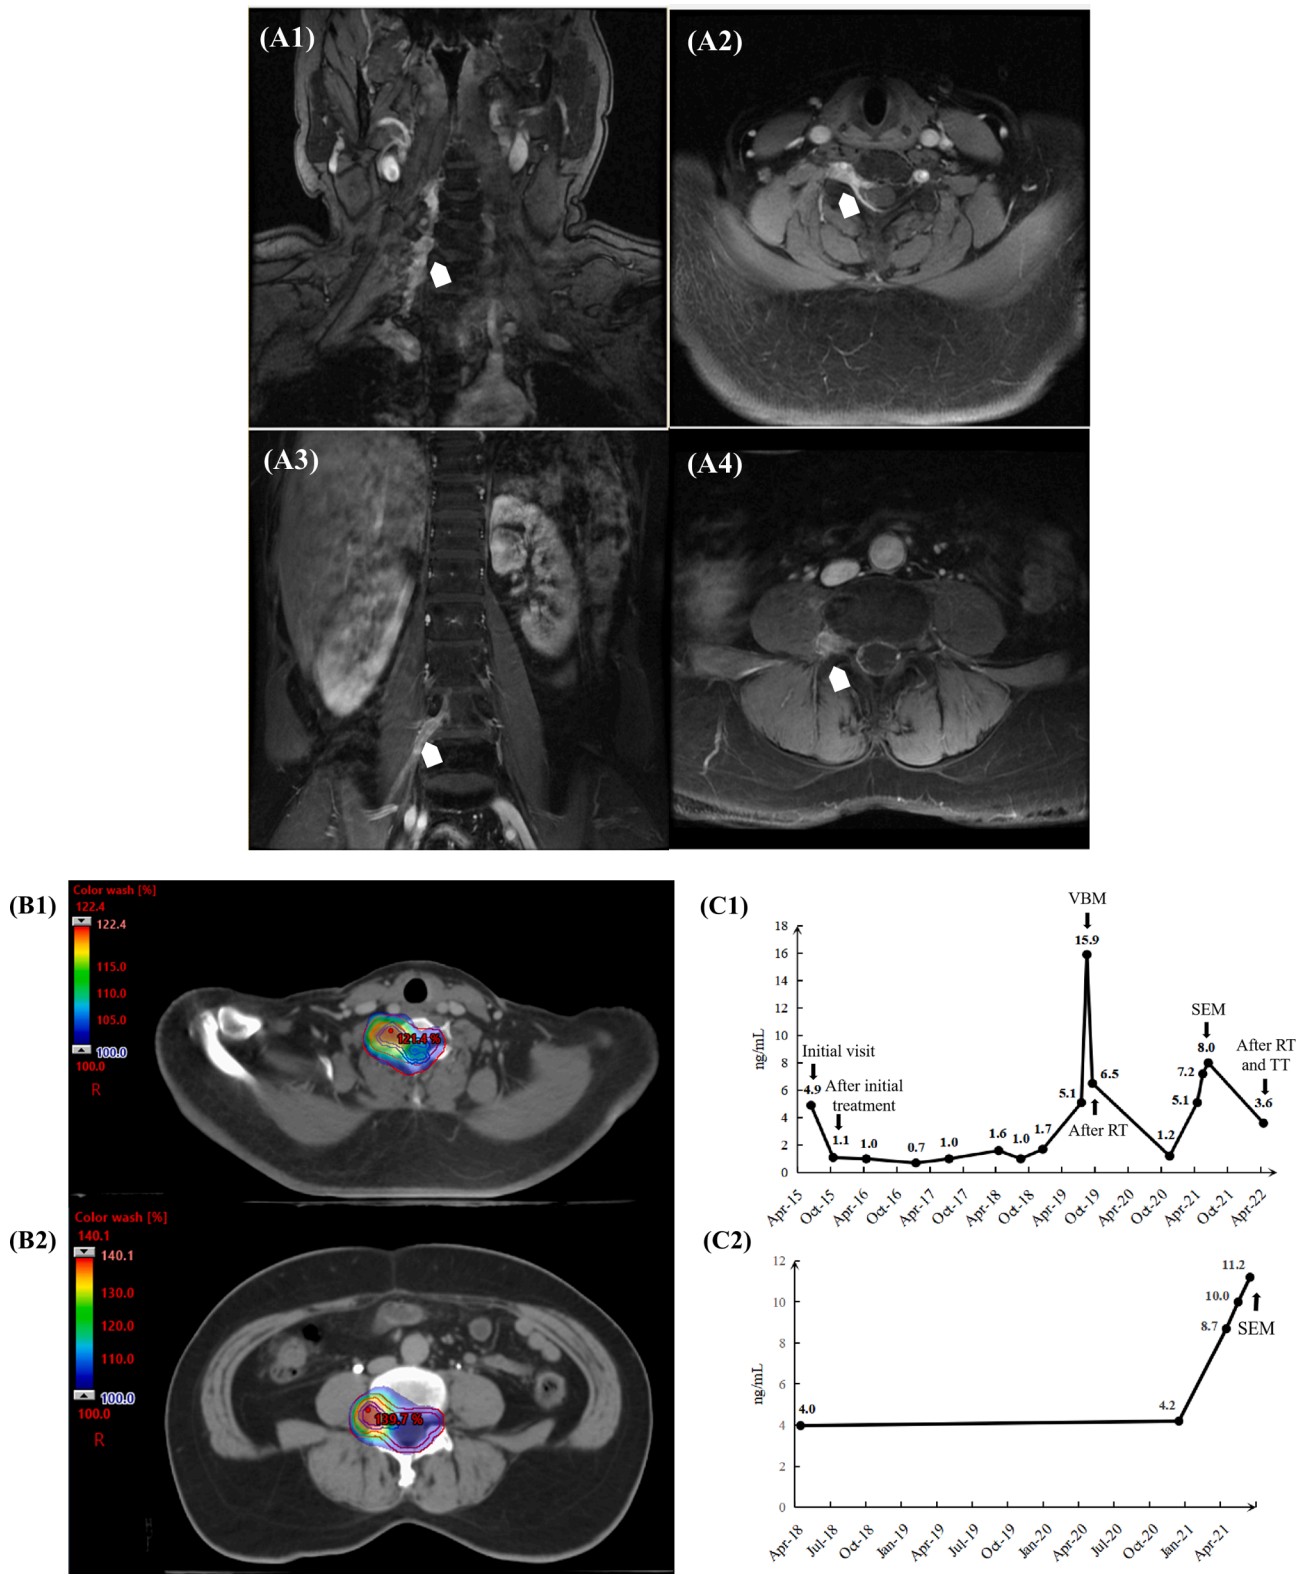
Case 2. (A)MRI: Cervical magnetic resonance imaging showed abnormal enhancement of spinal dura mater and widen right intervertebral foramen at C5-7 level. Coronal image(A1) and horizontal image(A2). Lumbar magnetic resonance imaging showed nodular obvious enhancement within dural sac at L3-4 level. Coronal image(A3) and horizontal image(A4). The arrows show lesion sites of spinal epidural metastasis. (B)Radiotherapy dose: The clinical target volume and dose distribution image of radiotherapy to spinal epidural metastasis. Cervical epidural metastatic area(B1) and lumbar epidural metastatic area(B2). (C)Tumor biomarker: The trend graphs of tumor biomarkers. Squamous cell carcinoma antigen, SCC-Ag (C1) and carcino-embryonic antigen, CEA (C2). Abbreviation: VBM, vertebral bone metastasis; SEM, spinal epidural metastasis ; RT, radiotherapy; TT, target therapy.
